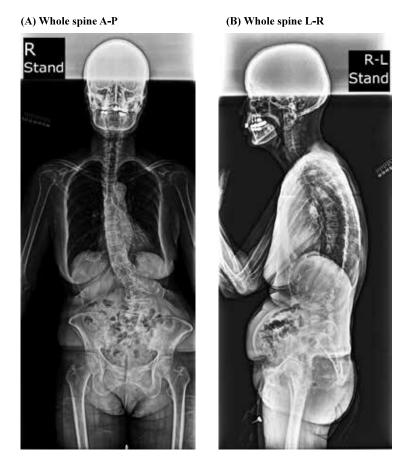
Preoperative X-ray images obtained for an 80-year-old woman with right leg pain. The whole spine view shows scoliosis in the front (A) and lateral (B) views.
